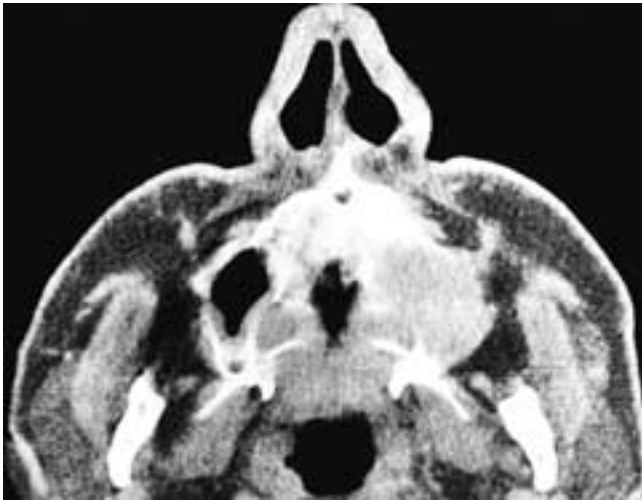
Axial CT scan shows an aggressively destructive lesion of the lower left antrum and palate. This patient had a squamous cell carcinoma.
